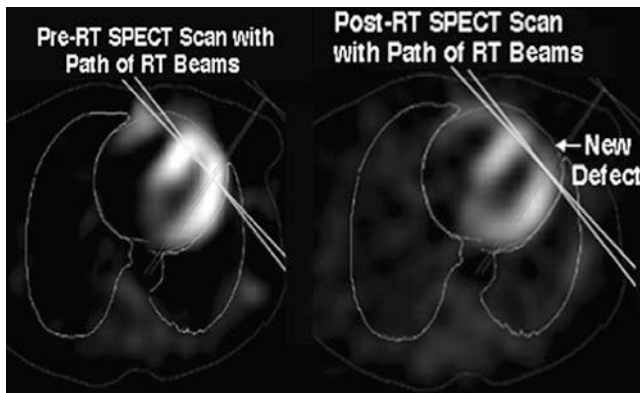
Representative axial images pre-RT (*left panel*) and post-RT (*right panel*) cardiac SPECT perfusion scans. The deep borders of the tangential RT beams are shown as *solid lines*. A new perfusion defect in the anterior left ventricle after radiation is seen (From Darby IJROBP 2010)
